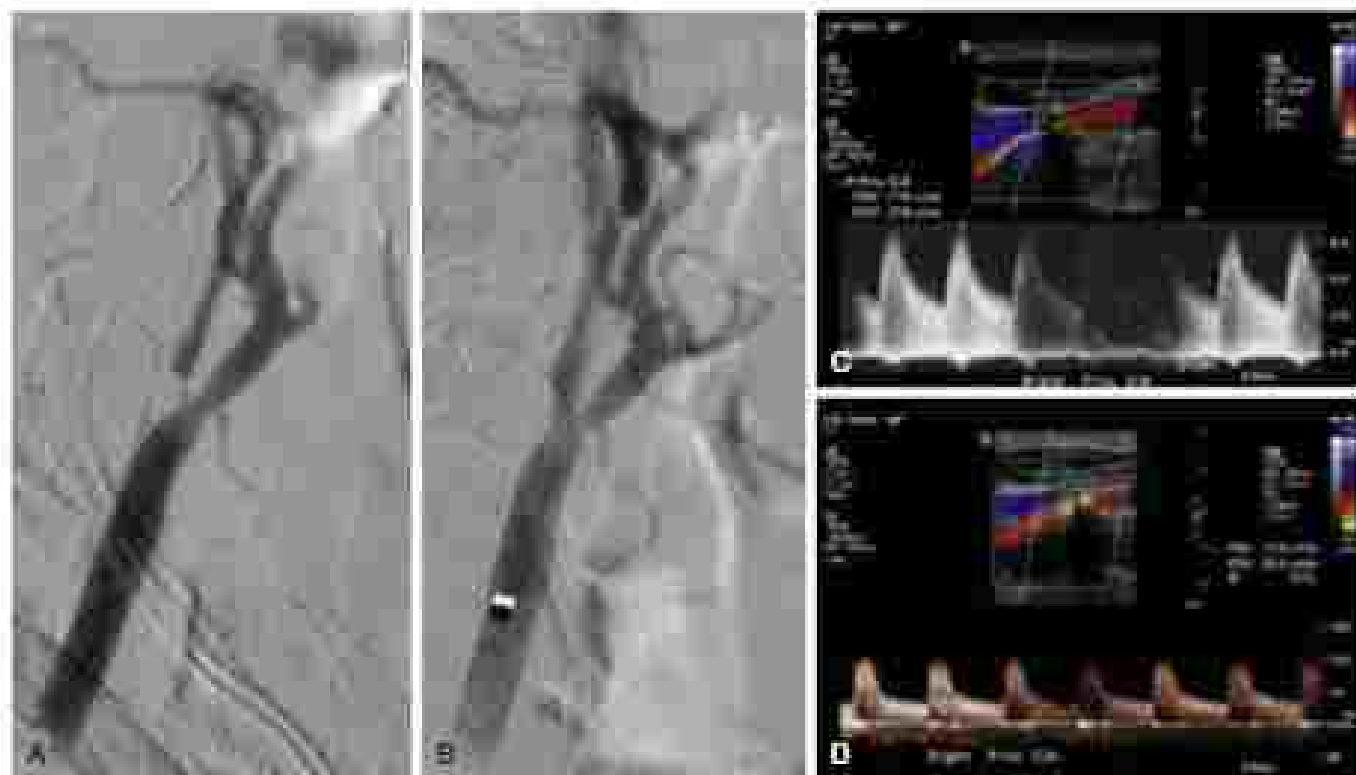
Patient (type II) carotid in-stent stenosis (ISR) is a 58-year-old man with high-grade asymptomatic ISR 1 year after initial carotid angioplasty and stenting. (A) Carotid angiography demonstrated a string sign of the proximal internal carotid artery (ICA) with approximately 95% stenosis. (B) The stenosis was managed with carotid angioplasty with antibiotic protection followed by placement of a self-expanding 7 × 30 mm stent. Postoperative angiogram is demonstrated. (C) Preoperative duplex ultrasound demonstrated severe IP with peak systolic velocity (PSV) of 110 and diastolic velocity (LDV) of 17. (D) Post-ICA-common carotid artery (CCA) ratio of 0.21. (E) Duplex ultrasound obtained 1 month postoperatively demonstrated PSV of 120, LDV of 23, and ICACCA ratio of 1.1.
